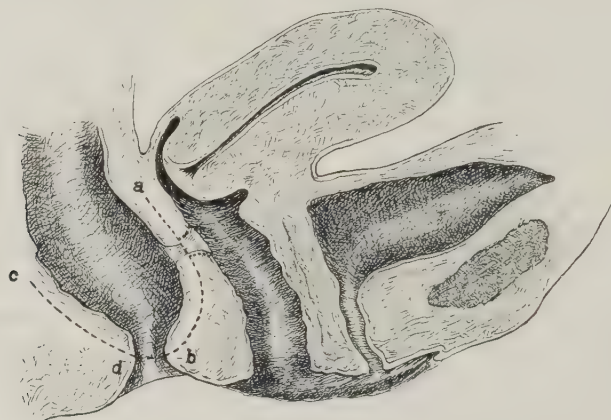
OPERATION FOR RECTOVAGINAL FISTULA BY CIRCUMFERENTIAL EXCISION OF THE RECTAL FISTULA-BEARING MUCOSA, AND DENUDATION AND CLOSURE OF THE VAGINAL ASPECT OF THE FISTULA — Marchand's Operation; — The fistula is seen in the rectovaginal wall. An extensive Whitehead operation (Vol. V, p. 158) is performed, freeing the rectal wall high up, along the lines *a*, *b* and *c*, *d*, and dividing the fistula midway between the vagina and rectum.
